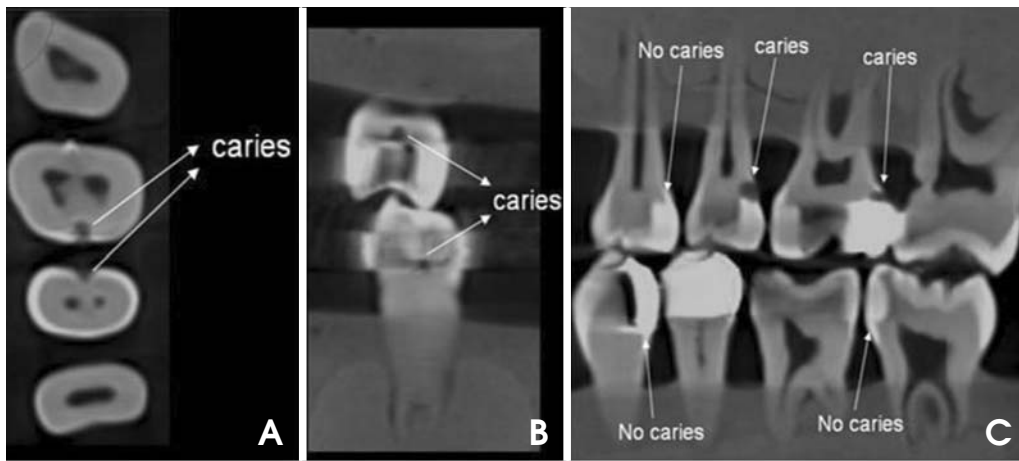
Examples of CBCT images demonstrates either secondary caries present or absent. A. Axial plane. B. Coronal plane. C. Sagittal plane.
